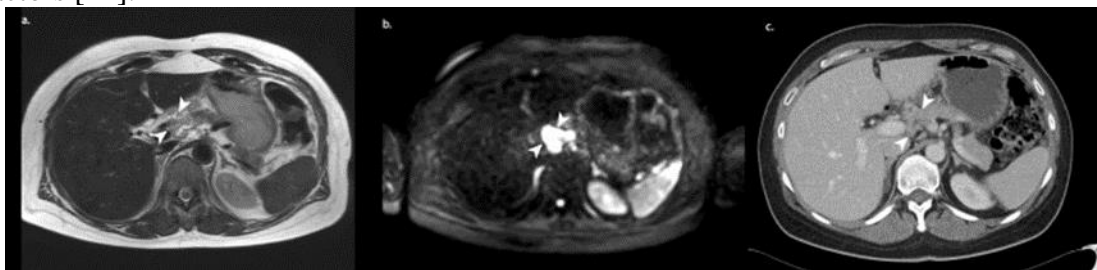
MRI staging example of a 56-year-old female after three courses of neoadjuvant chemotherapy. On diffusion-weighted imaging (b), a conspicuous lesion (arrowheads) is found in the area of the hepatic hilum. On T2 weighted imaging, the lesion can be distinguished as malignant. With CT (2 weeks earlier) alone, this large lesion largely “fades“ into its surroundings, making it difficult to spot and was therefore not mentioned in the original CT report. This extensive disease in the liver hilum, among others, rendered the patient inoperable [14].
